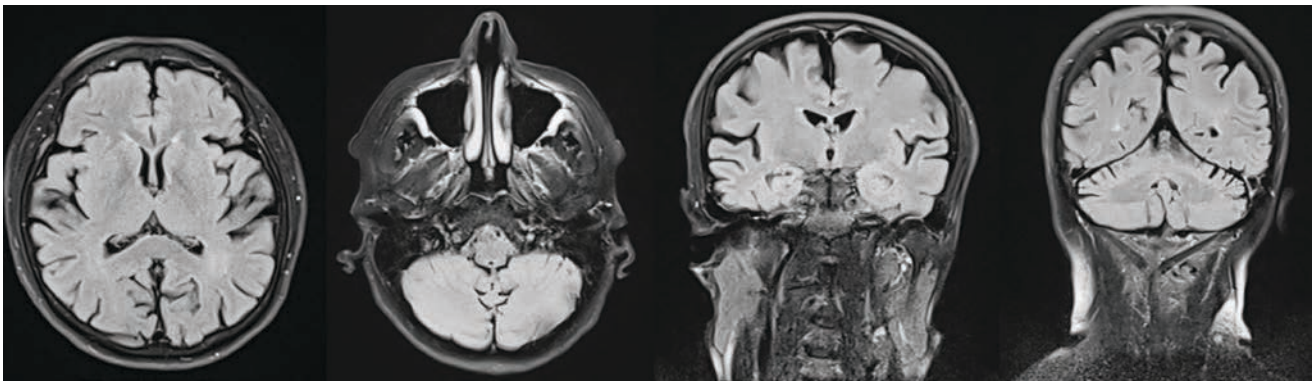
Brain MRI - FLAIR sequences showing a slight degree of cerebellar and cerebral atrophy
